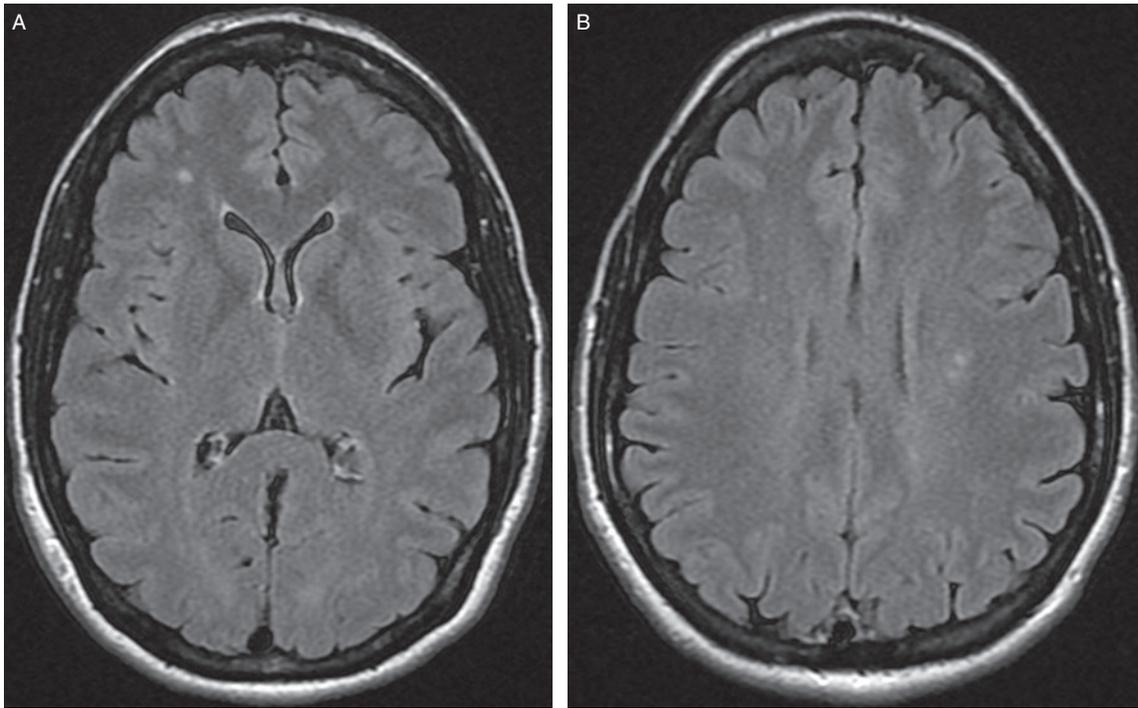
Axial FLAIR MRI brain showing commonly found, non-specific, randomly placed signal change, not highly suggestive of MS lesions.
